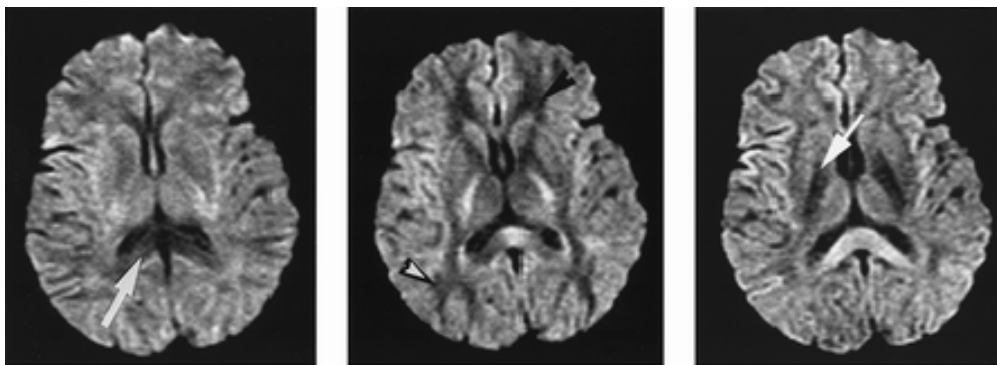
DW MR images, with diffusion gradients applied along the x (left), y (middle), and z (right) axes, demonstrating anisotropy in the brain. For example the corpus callosum (arrow on the left image) is hypointense when the gradient is applied in the x direction (right to left), the posterior white matter (arrowhead on the middle image) is hypointense when the gradient is applied in the y (anterior to posterior) direction, and the corticospinal tracts (arrow on the right image) are hypointense when the gradient is applied in the z (superior to inferior) direction. The ventricles are typical isotropic areas, presenting the same signal characteristics, independent of the direction of application of the diffusion gradients. (*Adapted from Schaefer et al., 2000*)
